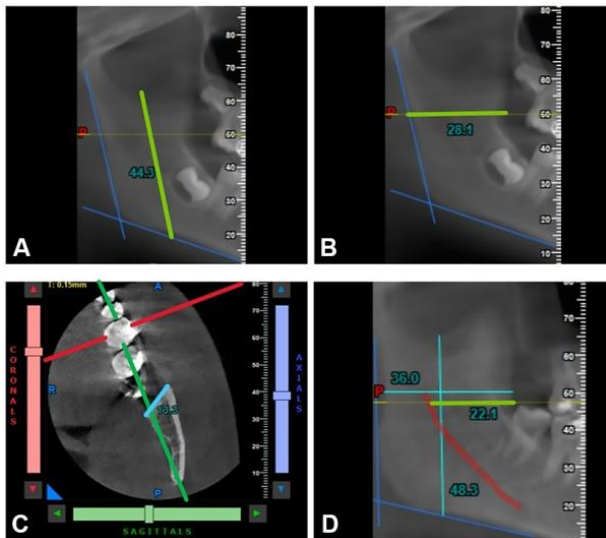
CBCT-based linear measurements of the mandibular ramus: (A) Ramal height, (B) ramal width, (C) ramal thickness and (D) IAN proximity
